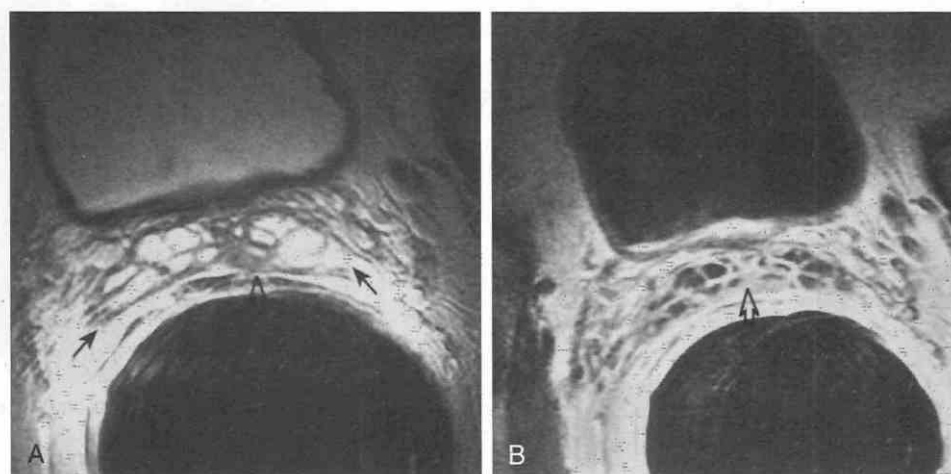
Early seminal vesicle invasion. A, Axial T2-weighted, fast spin-echo image of the seminal vesicles shows normal seminal vesicles laterally (black arrows). Centrally, however, the abnormal low-signal-intensity tumor tissue (open arrow) lying along the left seminal vesicle and surrounding the vas deferens represents early tumor invasion of the seminal vesicle. B, On the gadolinium-enhanced, T1-weighted image, the abnormal low-signal-intensity area enhances (open arrow), proving that it is solid tissue. The enhancement of the walls of the seminal vesicles is normal.
